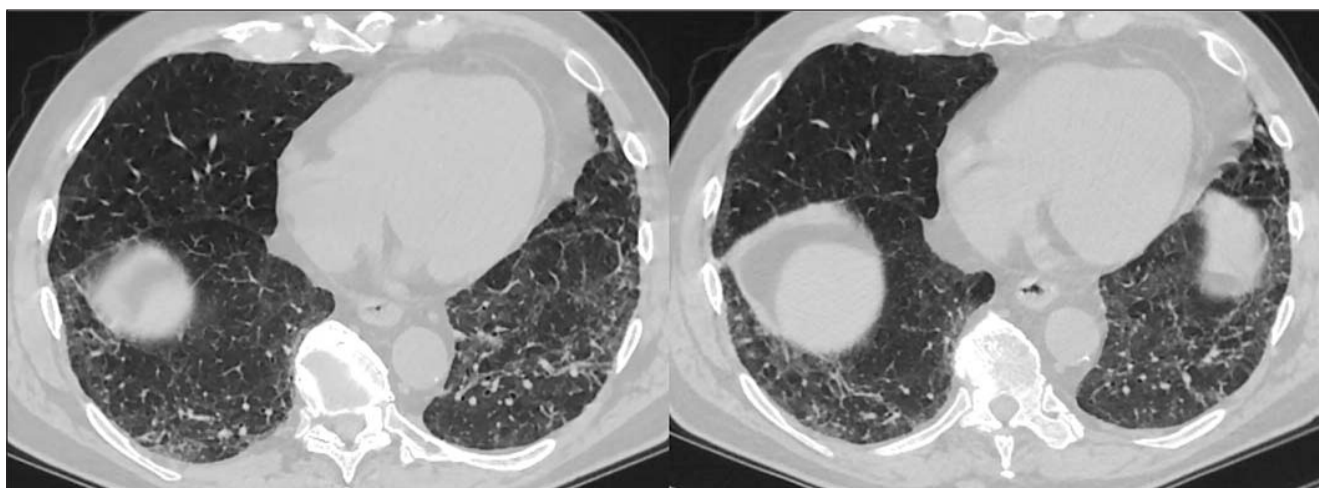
Lungs CT demonstratelobules some with patchy lucency due to bronchiolitis with air trapping.
